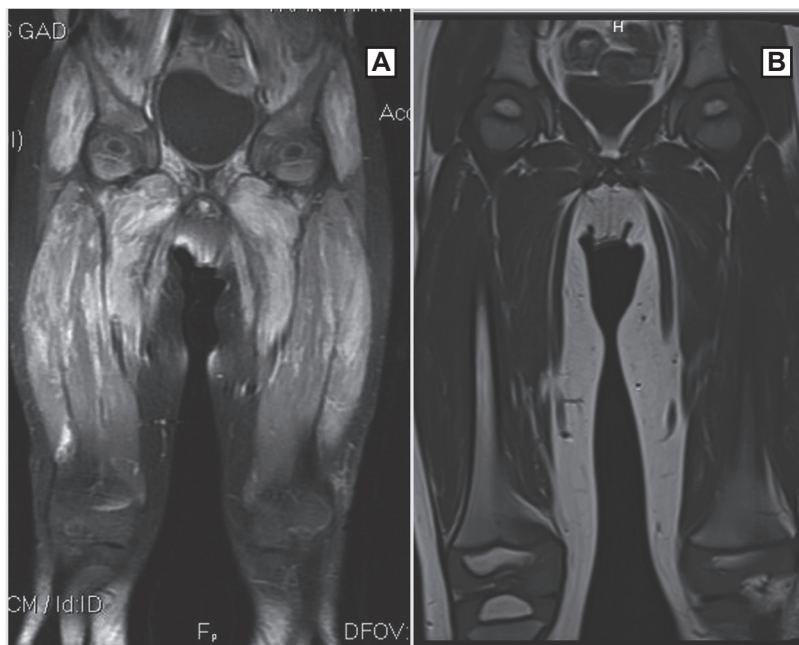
Diffuse inflammation of bilateral thigh muscle, high signal on T1 MRI before treatment (A), and image of thigh muscle returns to normal after one year of treatment (B)
